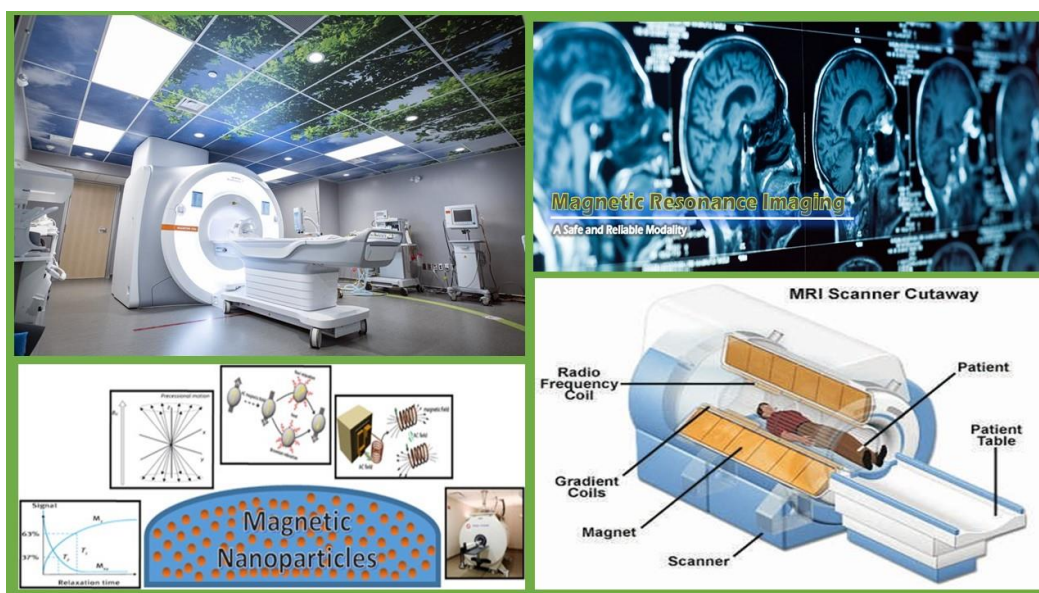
MRI - Magnetic Resonance Imaging
